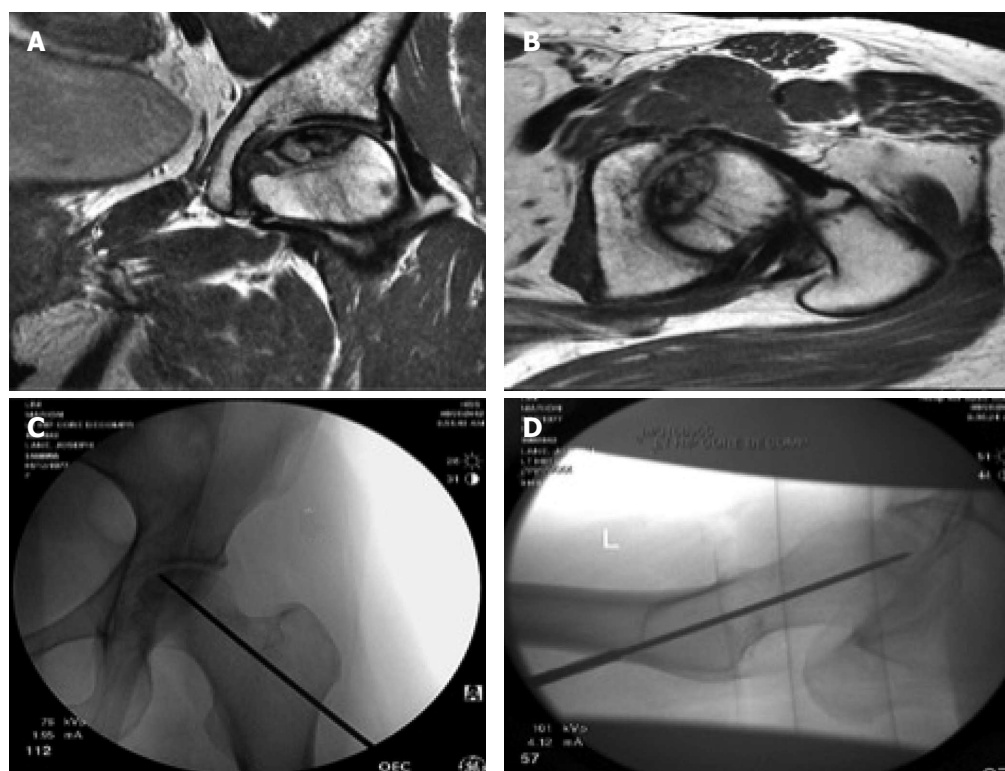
Core decompression of the left femoral head. Preoperative magnetic resonance imaging, above (coronal and axial views) and fluoroscopic imaging during the procedure below.
